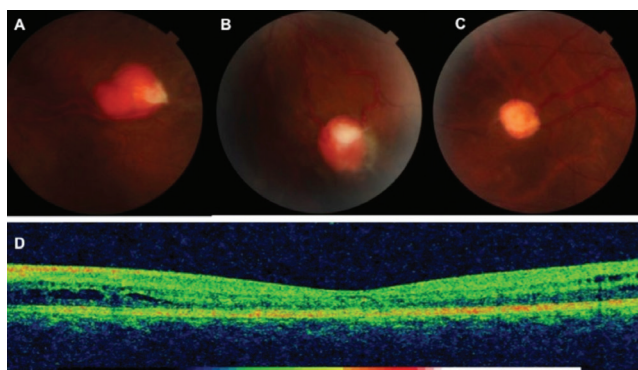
Retinal hemangioblastomas located in the (A) superotemporal left eye, (B) inferotemporal left eye, and (C) peripheral right eye, (D) Ocular computed tomography image showing perifoveal intraretinal cystic fluid accumulation
